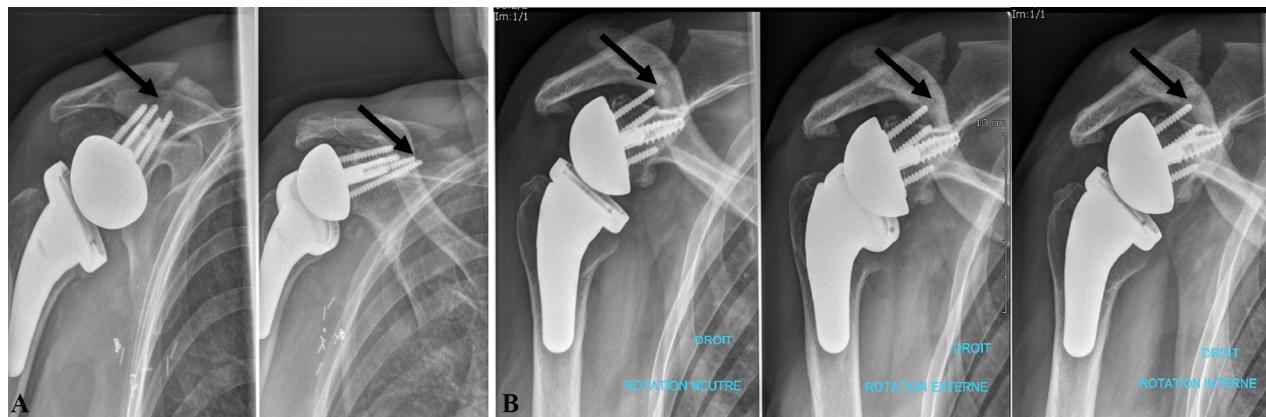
(A, B) Evidence of baseplate screw tip relationship with fracture line (black arrows) on plain radiographs.
